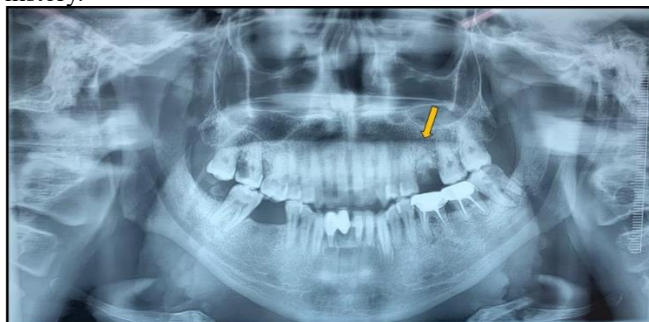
OPG reveals root stump i.r.t 26 with chronic periapical lesion (Indicated with yellow arrow).
